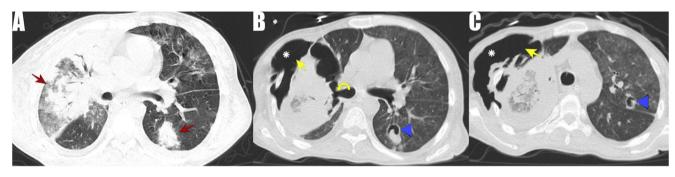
Computed tomography of the immunocompromised patient showed diffuse ground-glass densities in both lungs. Red arrows show ground-glass densities, consolidated areas (A). Yellow arrows show pleural rupture. White asterisks indicate the area of subcutaneous emphysema, yellow curved arrow indicate bronchopleural fistula, blue arrowheads indicate different aspergillomas showing the air crescent (B and C).
